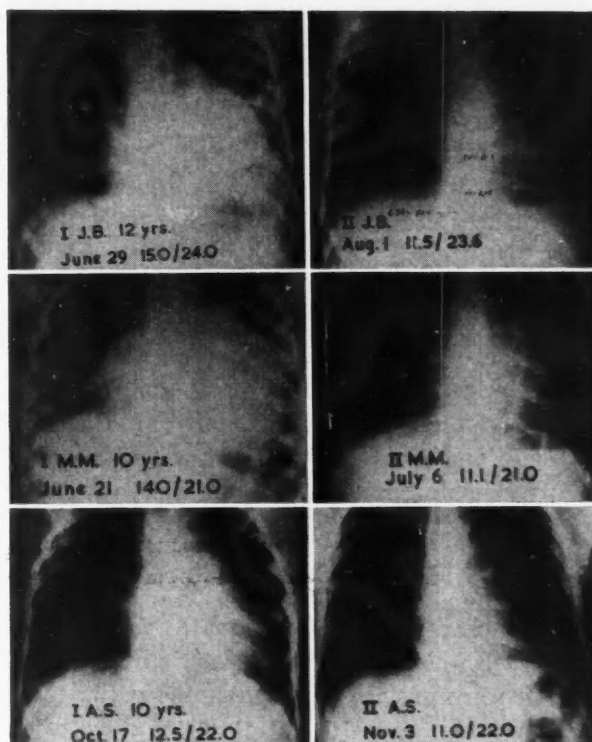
Above are shown the x-rays of 3 selected cases of acute rheumatic heart disease, treated with salicylates in 1940. The first x-ray in each case was taken on admission to hospital; the second x-ray two to four weeks later. Marked decrease in heart size is shown in each case over a relatively short interval.
